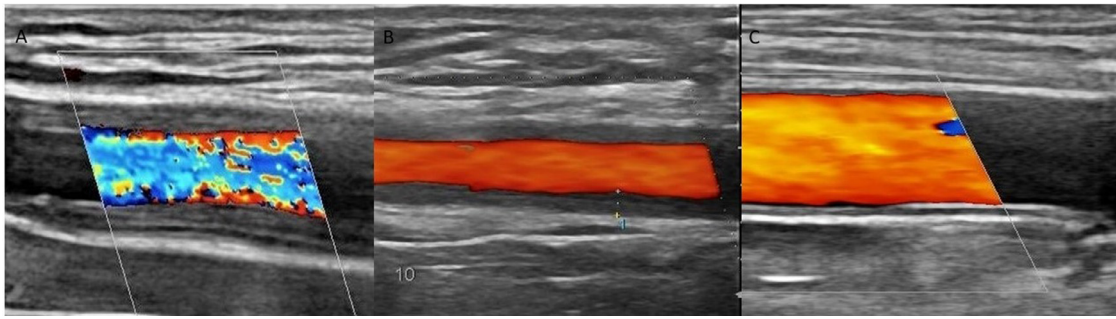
Ultrasound images of the axillary artery from the web-based exercise
